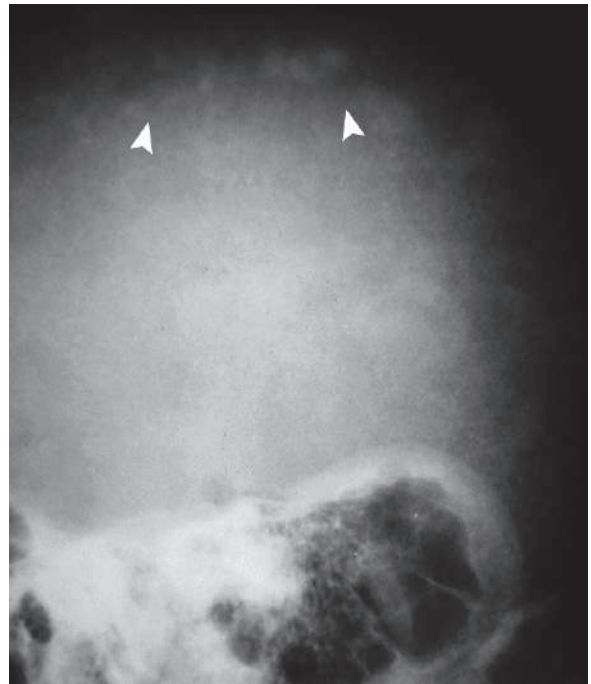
A lateral plain radiograph of the skull shows mild salt and pepper skull lesions in a patient with primary hyperparathyroidism
